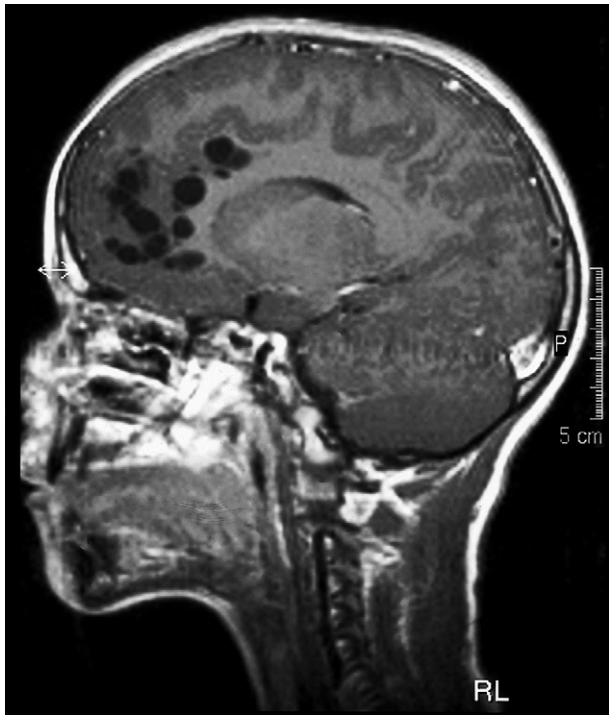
Sagittal T_1 -weighted magnetic resonance image after contrast injection (TR/TE = 596/15 ms). No enhancement is present.
